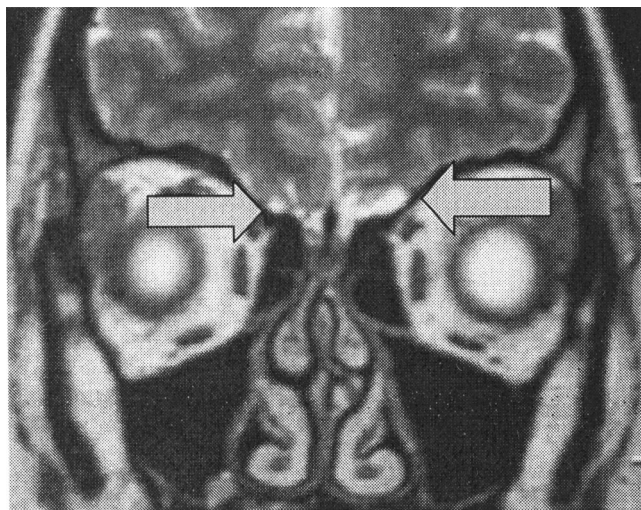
T2-weighted coronal image with decreased olfactory bulb volume and moderate damage in the frontal lobe area (arrows).
